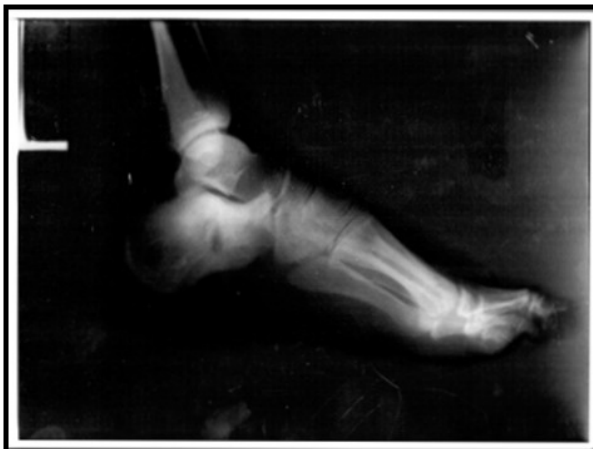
Radiographic imaging.
